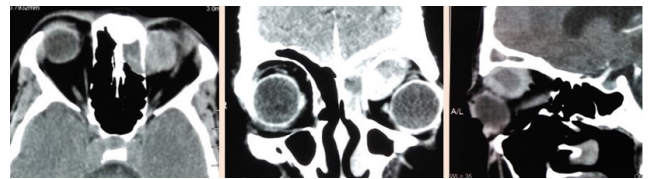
Enhanced heterogeneous lesion involving the superomedial quadrant of the left orbit with subtle extending into the left fronto-ethmoid sinuses on axial, coronal and sagittal images of CT scan of the orbit.
